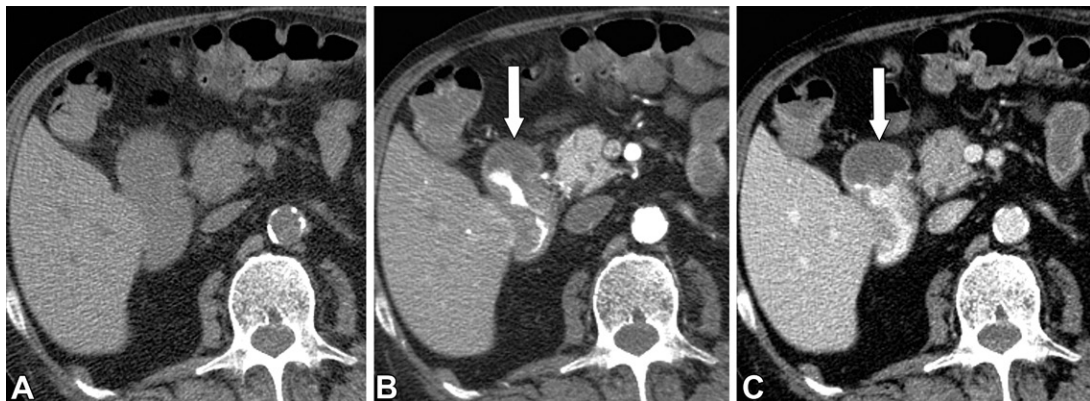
Active bleeding in the proximal duodenum, which was caused by two bleeding duodenal ulcers that were identified with endoscopy (not shown), in a 71-year-old man who presented with melena, hypotension, and shock. Axial noncontrast (A), arterial phase (B), and portal venous phase (C) CTA images show contrast extravasation in the proximal duodenum, which appears in the arterial phase (arrow in B) and changes in size, attenuation, and shape in the portal venous phase (arrow in C). The bleeding duodenal ulcers noted at endoscopy were not visualized on CT images.
